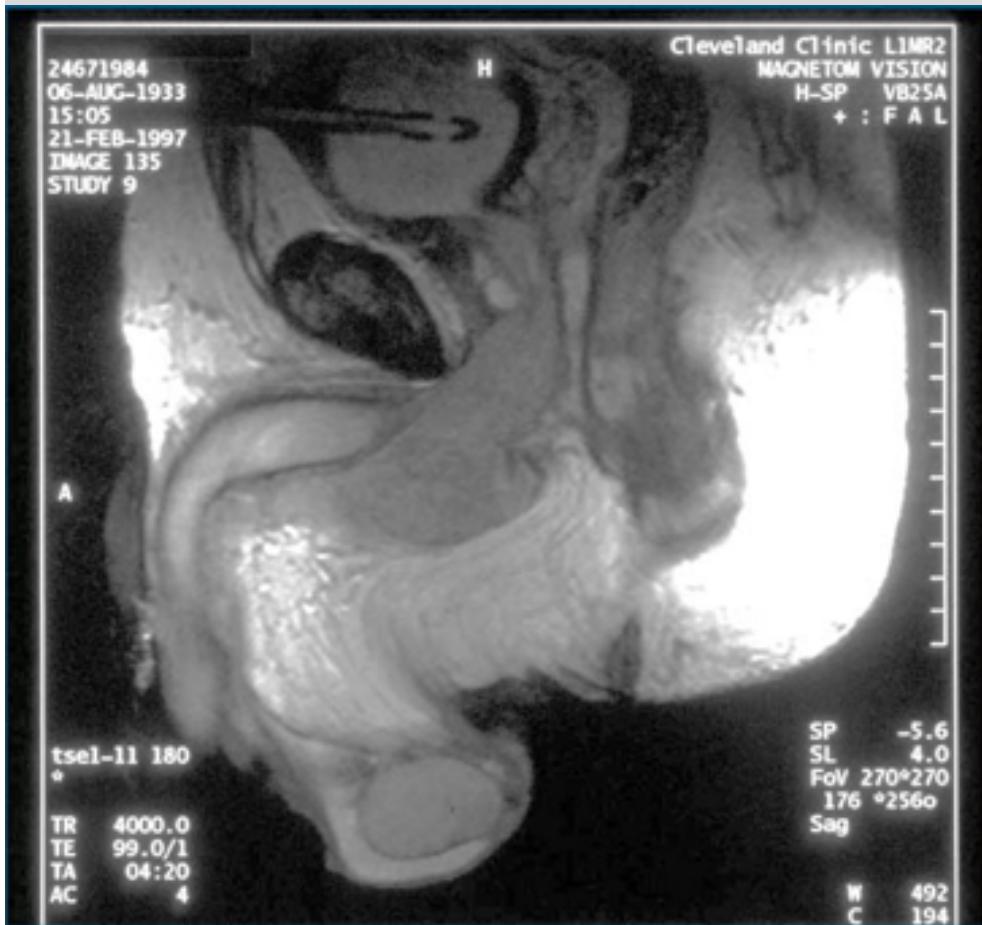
Sagittal MRI of a urethral mass extending from the bulbar urethra through the GU diaphragm to the prostatic urethra. (from Uzzo Penile Carcinoma 2019 AUA Board Review Course)
